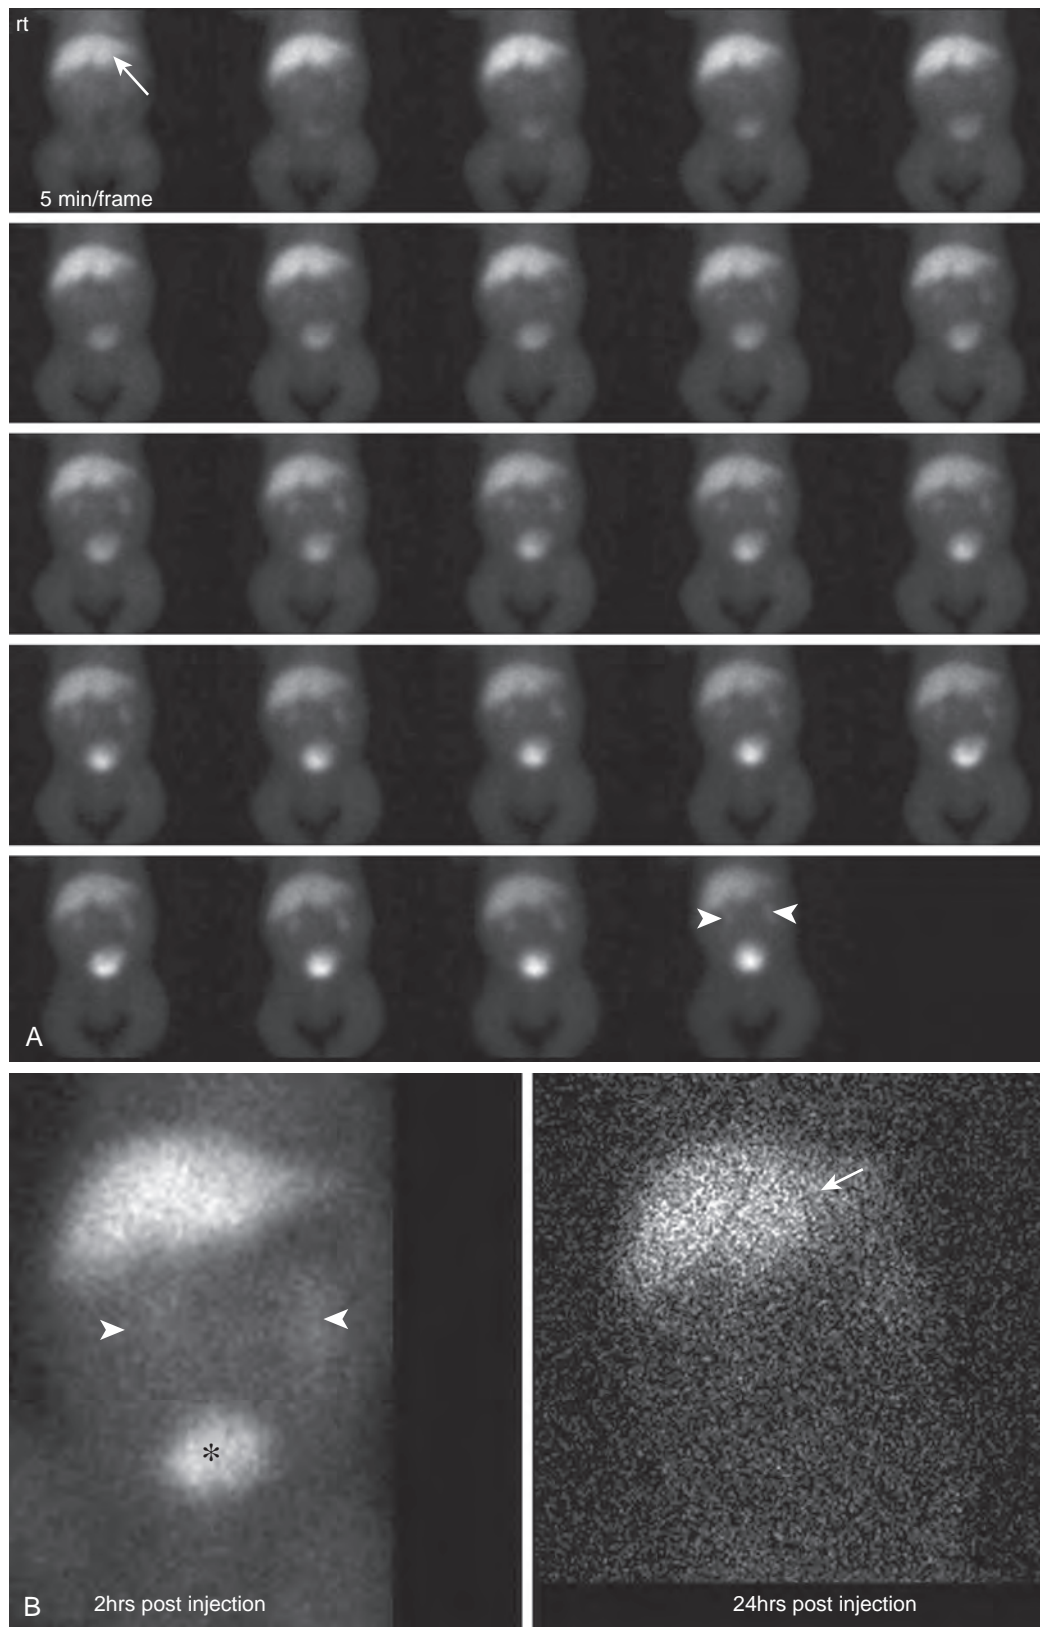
Biliary atresia: hepatobiliary nuclear scintigram. A. Anterior images of the abdomen and pelvis filmed at 5 minutes/frame demonstrate good uptake of ^{99m}Tc -disofenin by the hepatocytes in the liver (arrow). There is no evidence of activity in the gallbladder, common bile duct, or intestines. Renal uptake (arrowheads) and excretion into the urinary bladder are evident. B. Anterior delayed images. After a 2-hour delay, there is persistent activity within the liver and continued clearance by the kidneys (arrowheads) with excreted radiopharmaceutical detected within the urinary bladder (asterisk). The 24-hour image also demonstrates some activity in the liver (arrow) but no evidence of biliary excretion into the small intestine.
